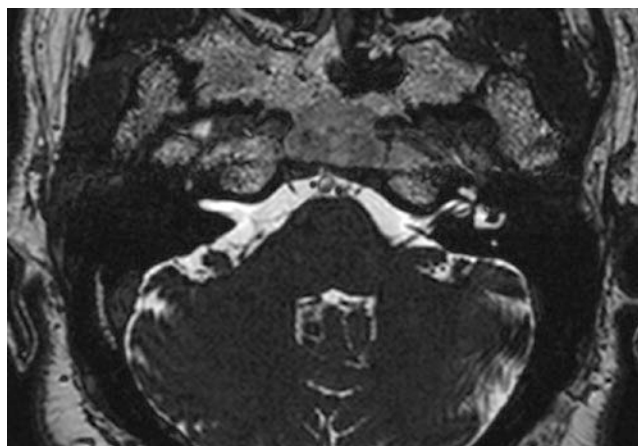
Labyrinthitis ossificans on the right with loss of fluid signal intensity on heavily T2-weighted sequence images
